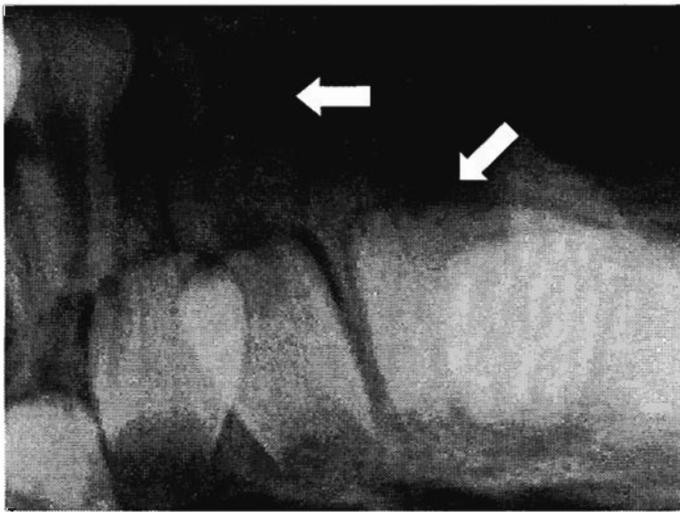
X-ray of the anterior mandible of a five-year old child from the Columbia River Plateau. The arrow on the left indicates the complete fusion of the deciduous right central and lateral incisors. The arrow on the right points to the possible presence of a geminated permanent left central incisor.
